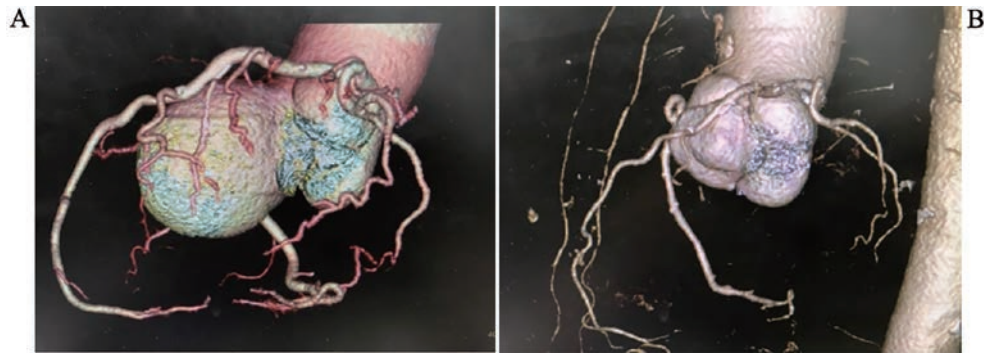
3D construction image of contrast-enhanced CT
